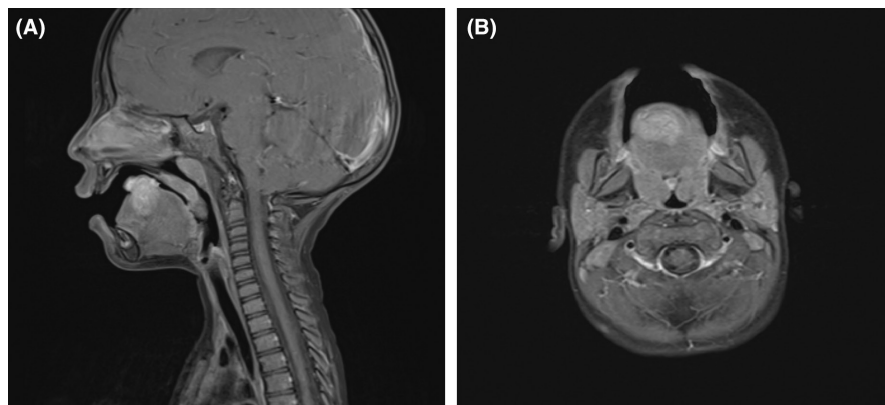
MRI of the tongue. Sagittal T1-weighted postcontrast image. (B) MRI of the tongue. Axial T1-weighted postcontrast image. Sagittal (Figure 1A) and axial (Figure 1B) T1-weighted postcontrast images clearly show a 2.3×2.1 cm mass with an exophytic portion in the area of the posterior tongue.
